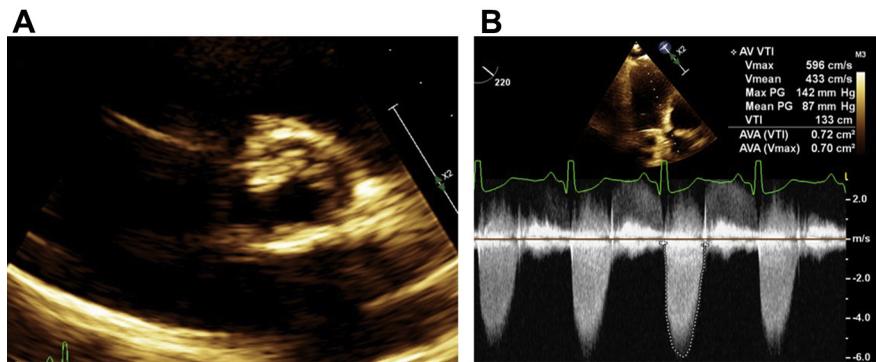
Severe aortic stenosis (AS). Severe AS with (A) Bicuspid, severely calcified aortic valve leaflets. (B) Extremely elevated gradients across the valve using continuous wave Doppler with maximum velocity of approximately 6 m/s.
